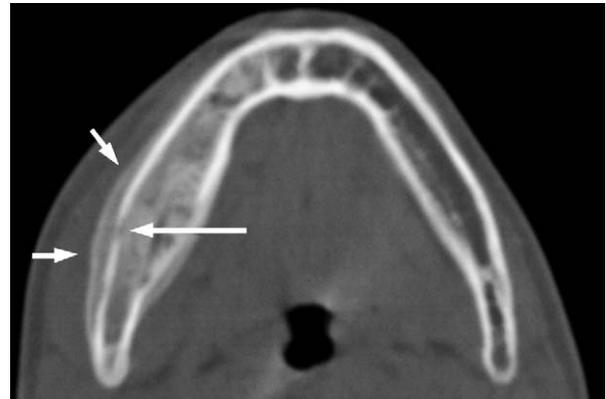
An axial CT image of bacterial osteomyelitis reveals lamellated periosteal reaction (short arrows) on the almost normal cortical bone around the perforated site (long arrow).
